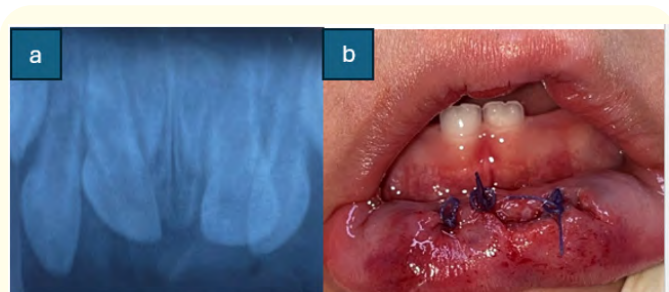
a: retroalveolar radiograph of the incisor region. b: inferior lip wound suturing.
